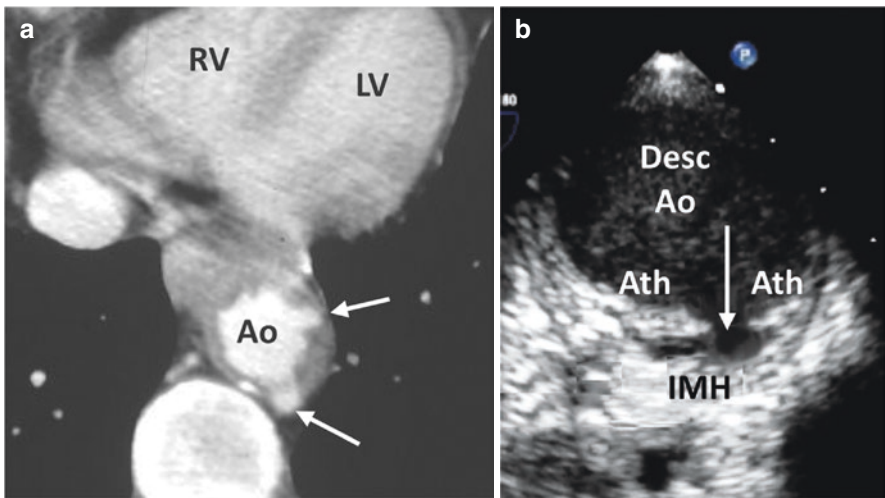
CT compared with TEE for Penetrating Aortic Ulcer. (a) CT scan showing two penetrating ulcers (white arrows) of the descending aorta (Desc Ao) (b) TEE showing penetrating ulcer (white arrow) through atherosclerotic intimal plaque (Ath) with intramural hematoma (IMH) in the Descending Aorta (Desc Ao). (with permission from Maslow et al. Journal of Cardiothoracic and Vascular Anesthesia, Vol. 32, Issue 3, p1341–1362)
